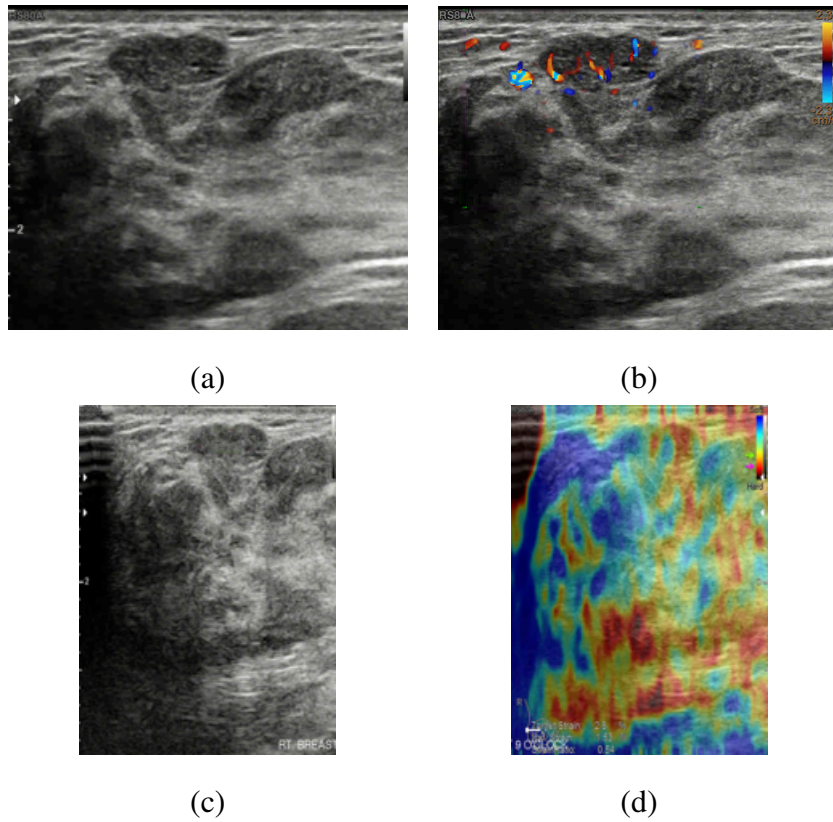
(a) convention US image. (b) Power Doppler image. (c) and (d) are conventional US and Elastography which are obtained simultaneously.
